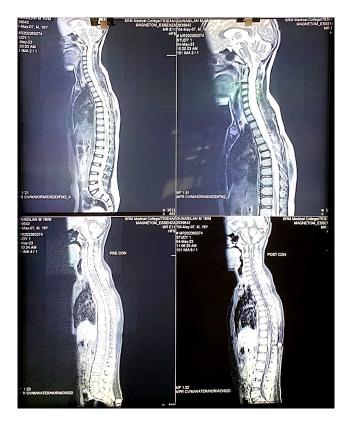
MRI cervical spine with whole spine screening showing a fluid filled cavity (Syrinx) from C1- D11 vertebral level MRI: Magnetic resonance imaging; C: Cervical; D: Dorsal
